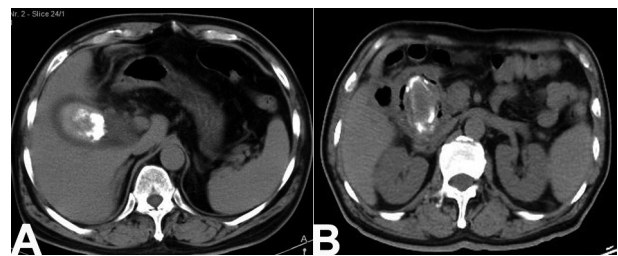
A : The CT scan displays a big gallstone in the gall bladder. B : The CT scan shows gas in the atrophic bladder and filling defect(gallstone) in the duodenum.
